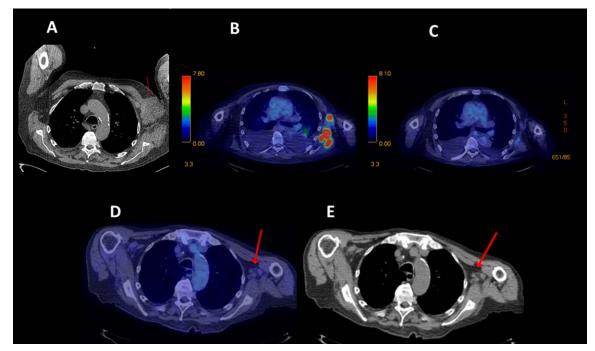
Partial response in diffuse large B-cell lymphoma. A 78-year-old man with diffuse large B-cell lymphoma diagnosed 3 years and six chemotherapy regimens before study entry. (A): Baseline computed tomography (CT) scan showing red arrow pointing to bulky left axillary mass. (B): End of cycle 2 positron emission tomography (PET) scan showing persistent left axillary glucose uptake in areas of lymphoma. (C): End of cycle 4 PET scan showing complete metabolic response. (D, E): End of cycle 14 PET and CT scans with red arrows pointing to ongoing complete metabolic response and nonpathologic residual nodes, respectively. After a gradual 90% decline in measured disease, at month 17 the subject's disease progressed distantly in the thigh, and study therapy was stopped.
